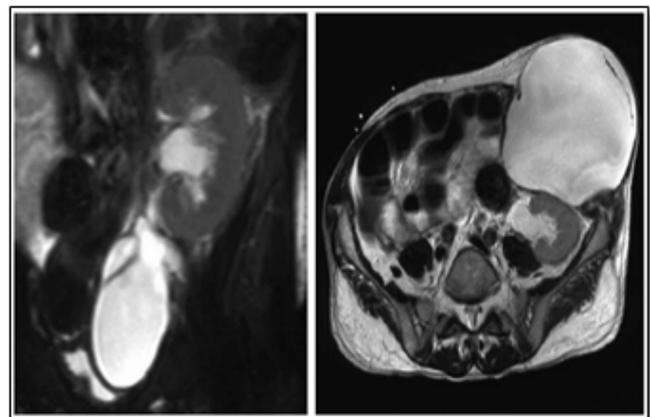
T2-weighted coronal and axial MR images showing the location of the lymphocele which is seated inferior and anterior to the allograft [9].
